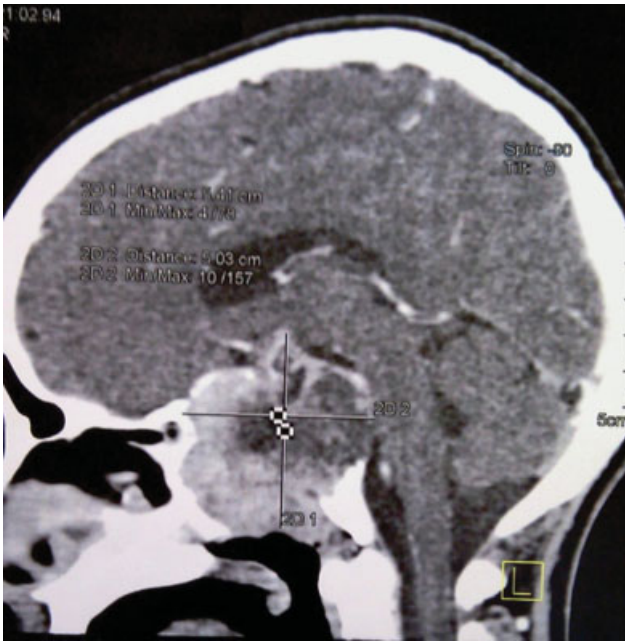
Contrast-enhanced, sagittal head computed tomography. Expansive process of massive volume eroding the sella turcica and the base of the skull with inferior extension to the sphenoidal sinus and progressing to the clivus and cavum region.
